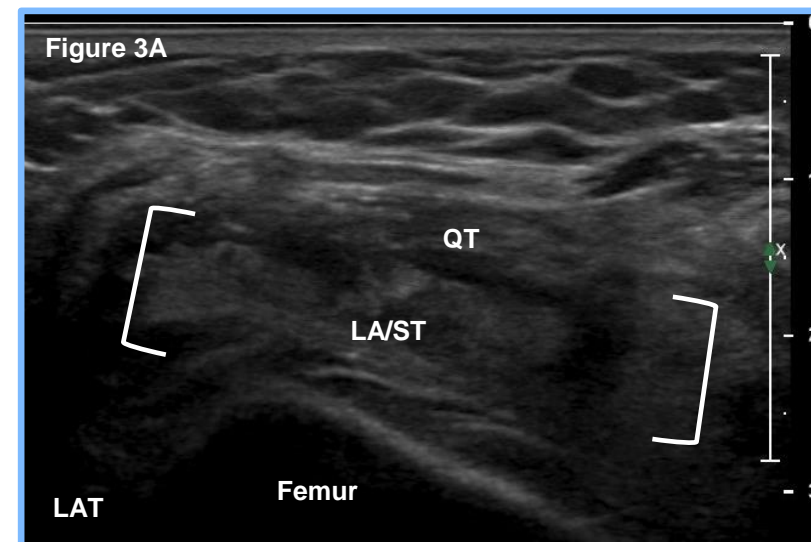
Sonographic anatomic transverse view of the suprapatellar recess deep to the quadriceps tendon (QT) and superficial to the femur. Note the presence of lipoma arborescens / synovial tissue (LA/ST, in brackets).
